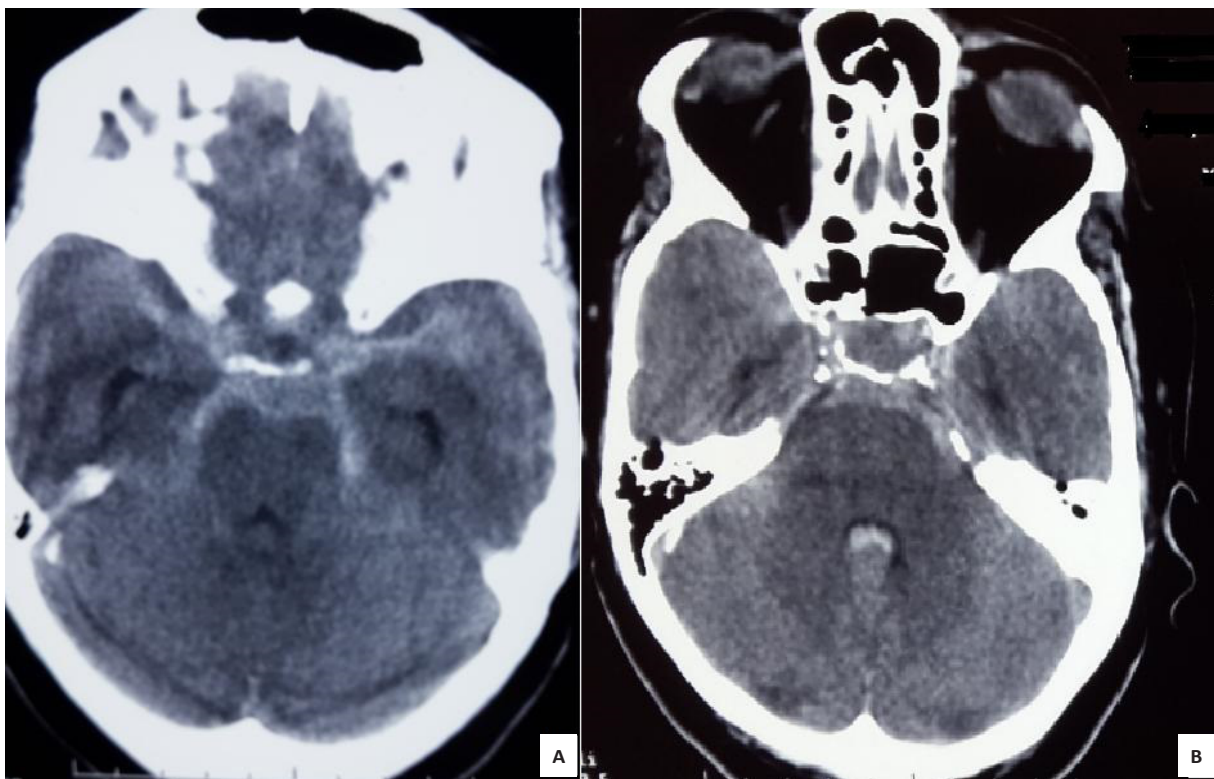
Preoperative cranial computerized tomography (CT) revealed subarachnoid hemorrhage (SAH) that was evaluated as grade 4 in Fisher scale and mild hydrocephalus; [A]: Perimesencephalic SAH and mild hydrocephalus are apparent in temporal horns of lateral ventricle; [B]: Fisher grade IV Intraventricular subarachnoid hemorrhage in the fourth ventricle.
